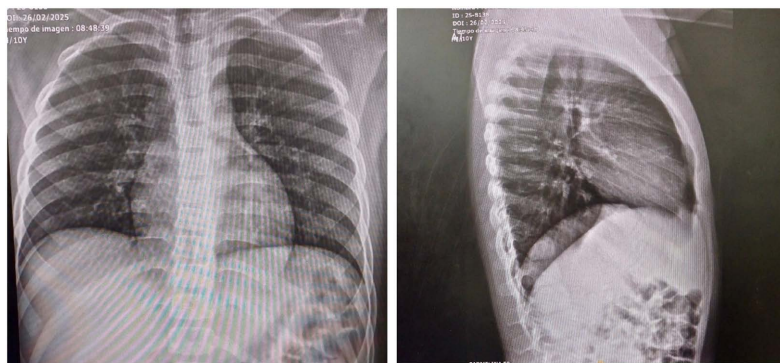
Chest X-ray showing normal cardiopulmonary findings at admission.
